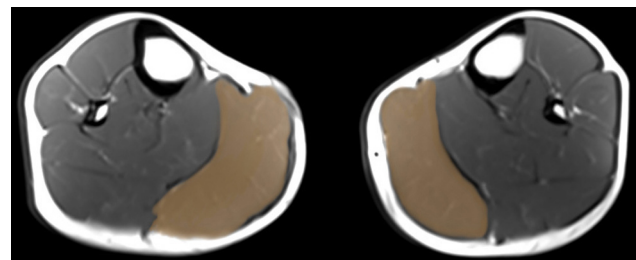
MRI axial slices. The muscular hypertrophy was mainly found in the posterior and medial compartments.
